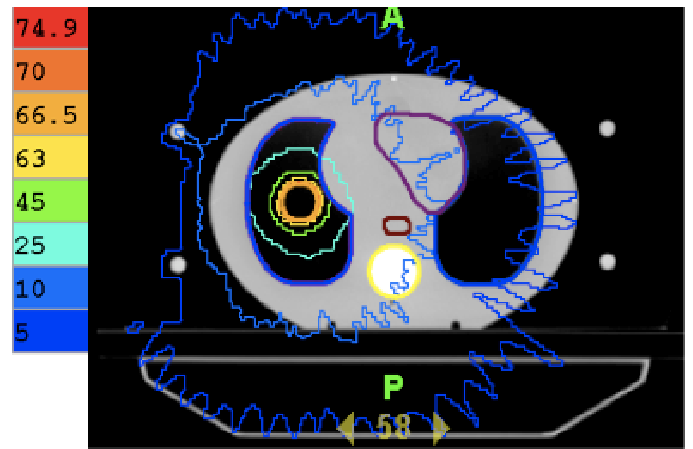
A transverse CT slice showing several isodose lines (including the 5 and 10 Gy lines) for the treatment plan developed with the 2.5 cm field width.
